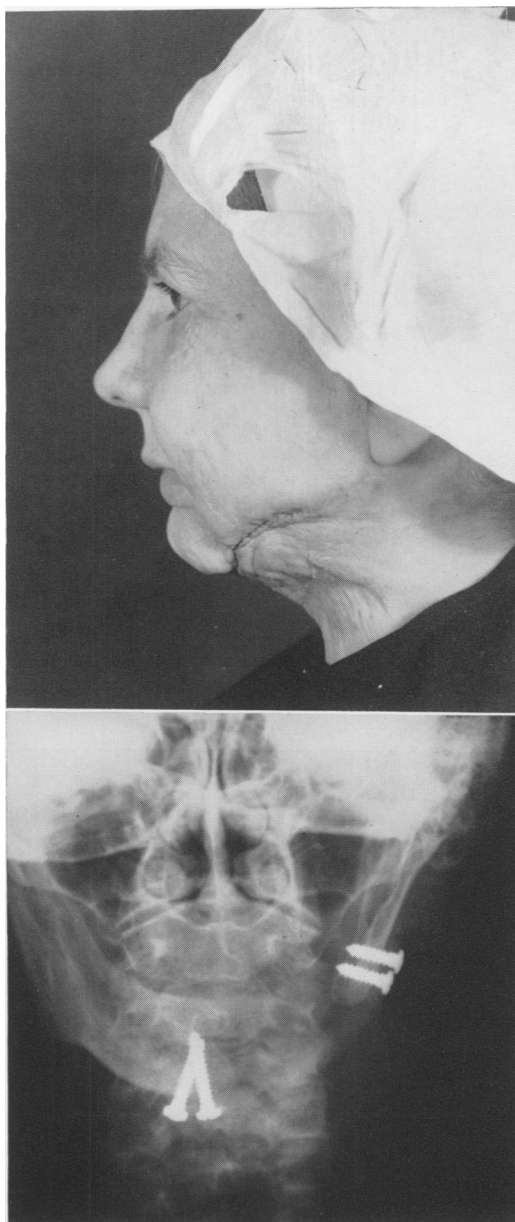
Carcinoma buccal mucosa. Radiation treatment followed by radical jaw-neck. Secondary permanent-pedicle blood-carrying flap closure. Jaw stabilized with bar of Teflon, for good function. The Sister returned to teaching. Teflon shown by four screws only as it is transparent to x-ray.
